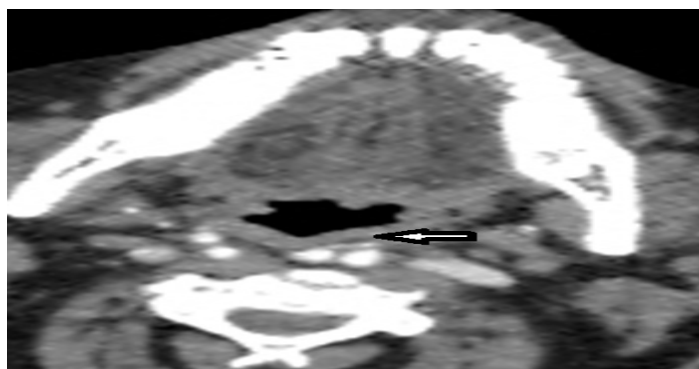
CT post contrast axial image showing significant indentation over retropharyngeal soft tissue on left side.
